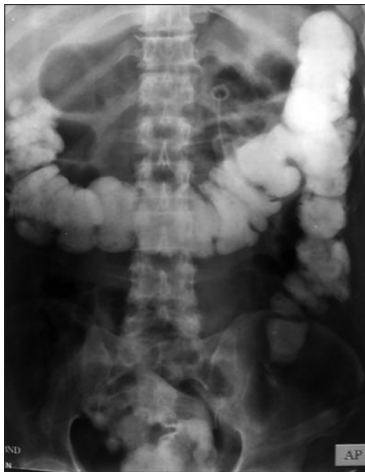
Post computed tomography scan abdomen roentgenogram after 72 h
